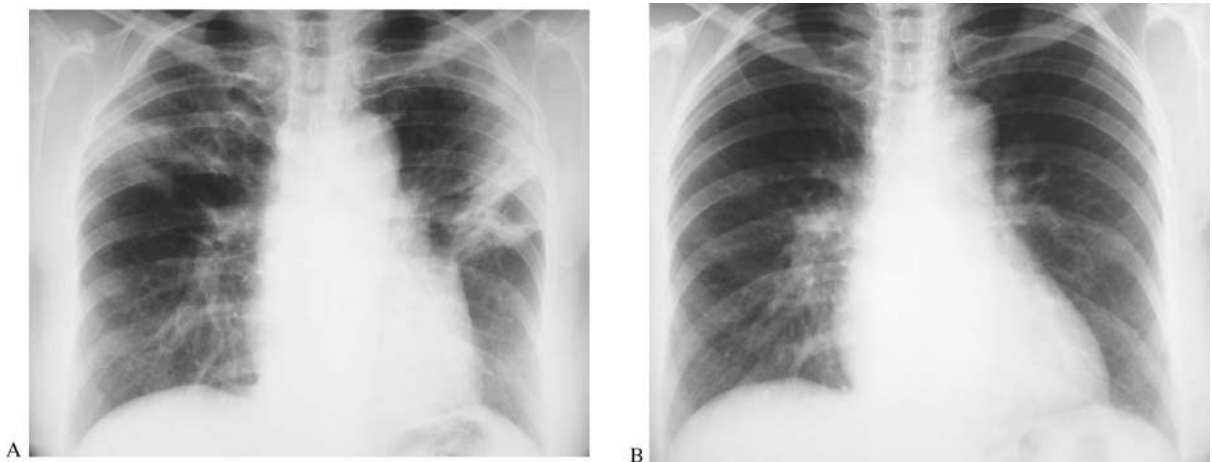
BOOP in a patient with rheumatoid arthritis under gold salts treatment. (A) Before steroid treatment chest radiograph shows bilateral patchy lung consolidation with associated architectural lung distortion. (B) After treatment, plain film shows complete resolution of the parenchymal opacities.
